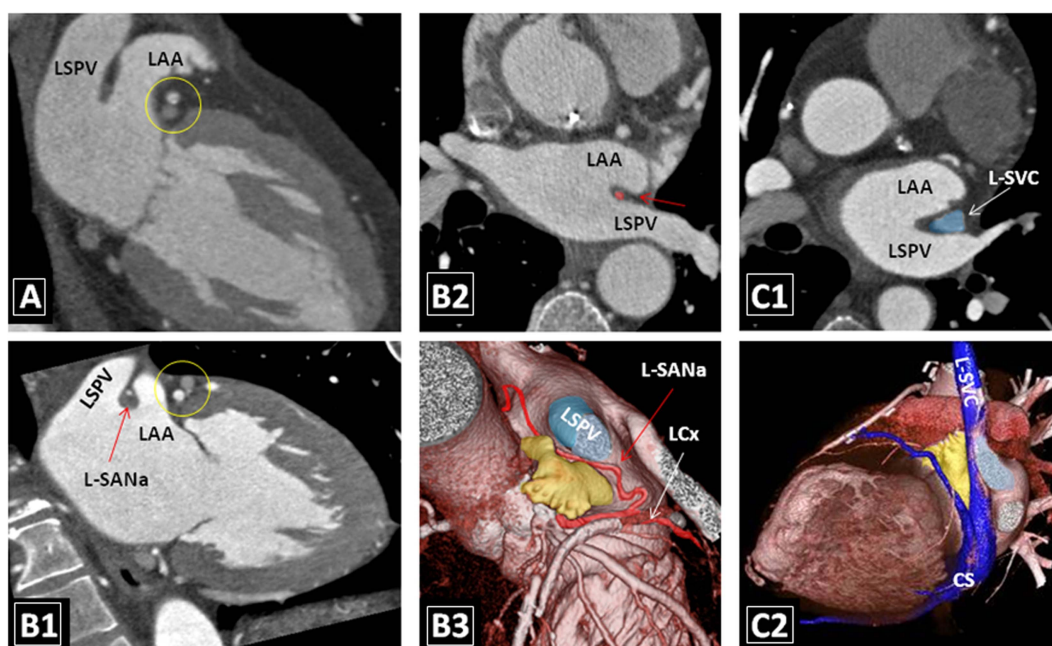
Relationship of vessels with the left atrial appendage (LAA). (A, B1) Left two chamber CT images showing the anatomic course of the left circumflex artery and great cardinal vein (within the yellow circle) in the atrioventricular groove and inferior to the neck of the LAA. (B1–3) In order, axial, two chamber, and left lateral volume rendered CT images showing the anatomic course of the S-shaped left sinoatrial node artery (L-SANa) in the groove between the LAA and the left superior pulmonary vein (LSPV). The S-shaped variant of the left SANa is seen in 14% of individuals and comprises 30% of the left SANa. (C1, C2) Axial and left lateral volume rendered CT images showing a persistent left superior vena cava (L-SVC) passing between the LAA and LSPV until it connects to the coronary sinus (CS). This variant is seen in <1% of the population but is more common in congenital heart disease.
